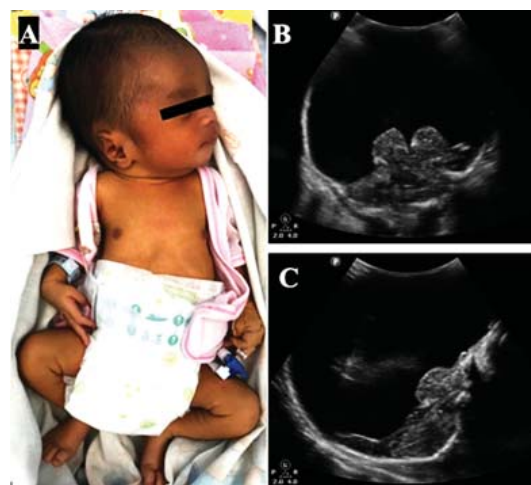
(A) General Appearance of The Newborn, (B) (C) 2D Transcranial Sonography (TCS) of The Newborn's Head (Mid-Coronal View) and (Mid-Sagittal View) respectively revealed absent of bilateral cerebral cortex with falx cerebri disruption; while midbrain structures, cerebellum and other posterior fossa structures are less visible.
